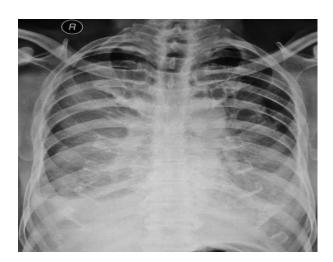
Plain frontal chest radiograph showing mediastinal widening with homogenous soft tissue opacity extending into the both sides (right more than left), involving the mid and lower zones. There is bilateral costophrenic angle blunting.
